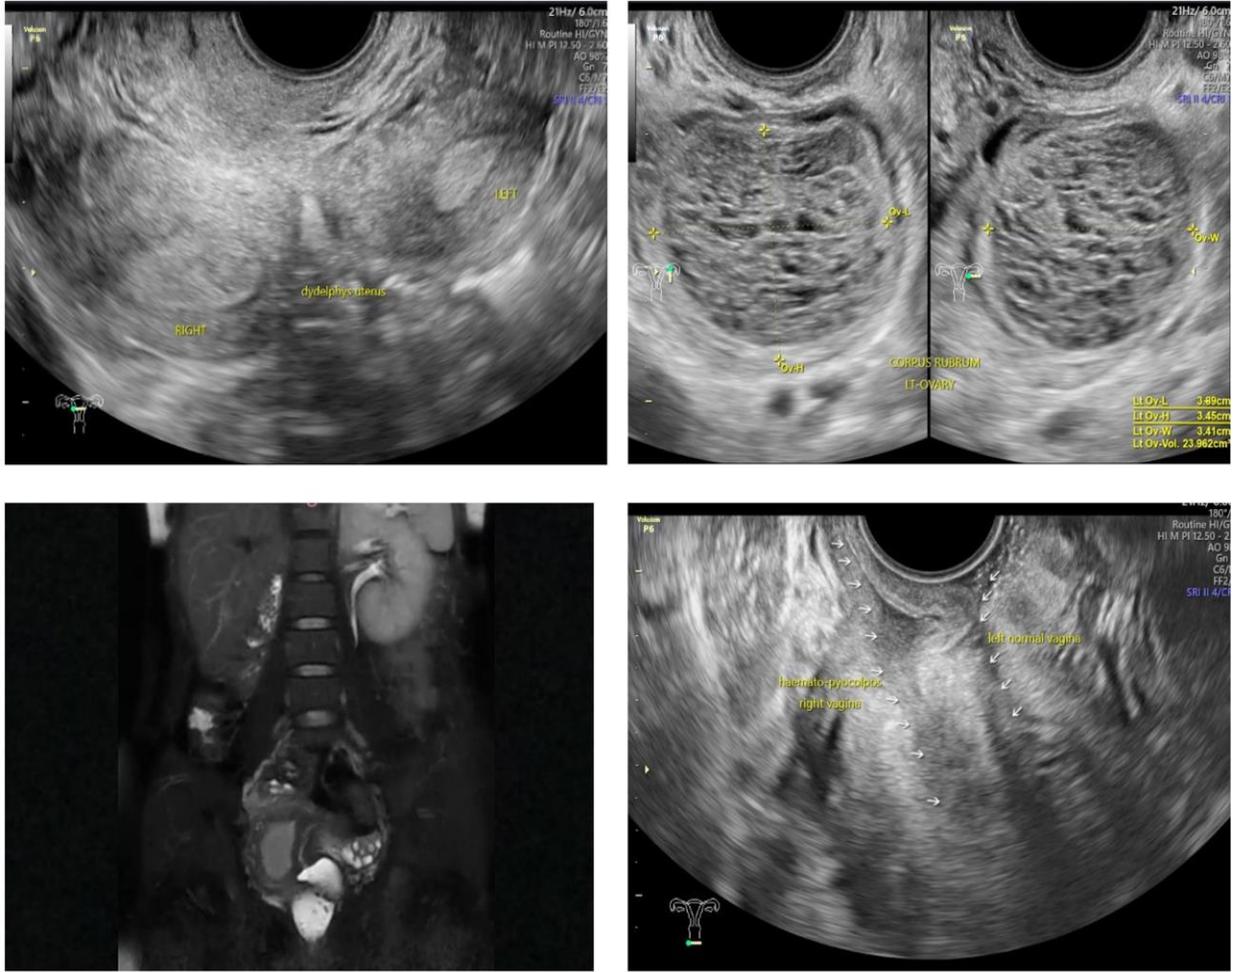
Ultrasound finding in Case 1 A) didelphys bicolis uterus, size: right 84x33x29 mm, vol 42.75 cm³, left 81x32x25 mm, vol 33.4 cm³. Homogenic myometrium. Endocervix and cervix within normal limit. B) Left ovary forming corpus rubrum, size 39x35x34 mm, vol. 24 cm³. no sign of solid part, papil growth, vascularization or free fluid. C) No sign of widened pelvio-calyces system of left kidney. Unidentified right kidney (MRI). D) Longitudinal vaginal septum divided left and right side, seen hemato-pyocolpos at right vagina. Positive sliding sign. US guided tenderness not found.
